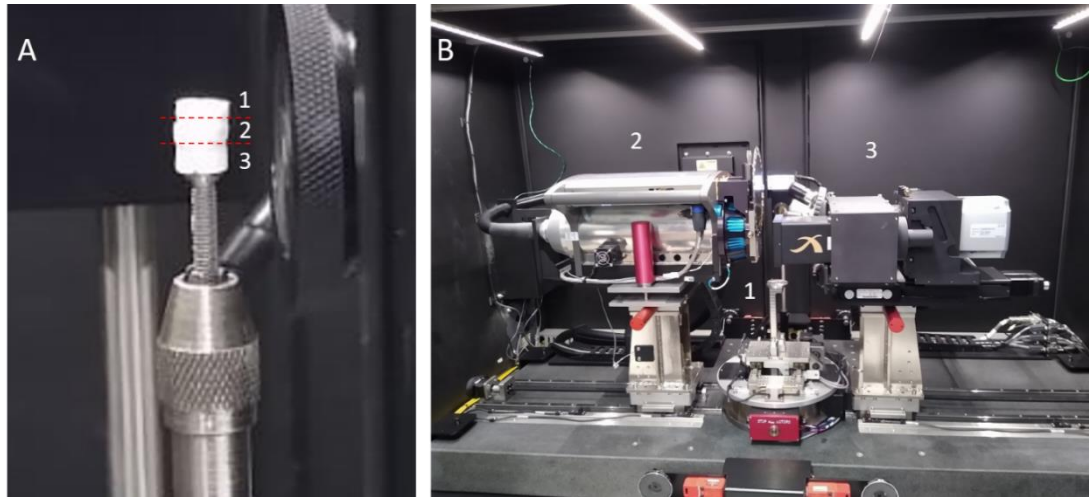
(a) 10% PVA aerogels prepared for Micro CT analysis.
